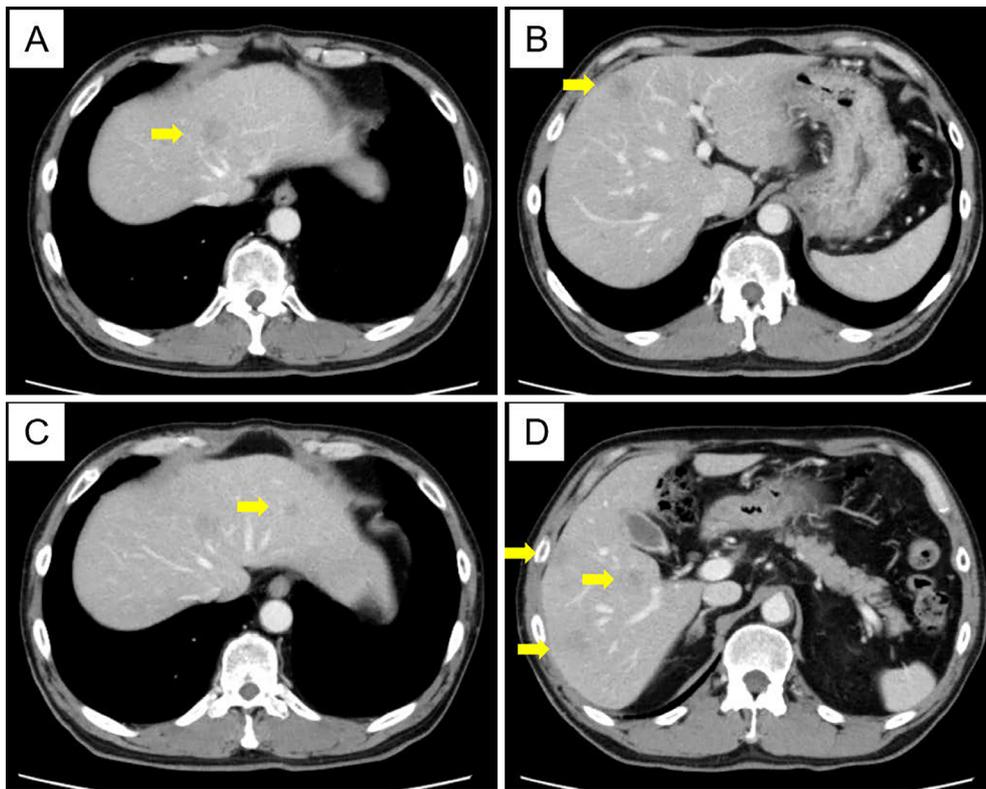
Abdominal CT images at referral to our division. Multiple spherical hepatic nodules, ranging in size from 1-3 cm, are distributed in both liver lobes (A-D, arrows). The nodules showed two types: those with well-defined borders (A, C) and those with ill-defined borders (B, D). The nodules had no capsular structure and very weak contrast enhancement.
